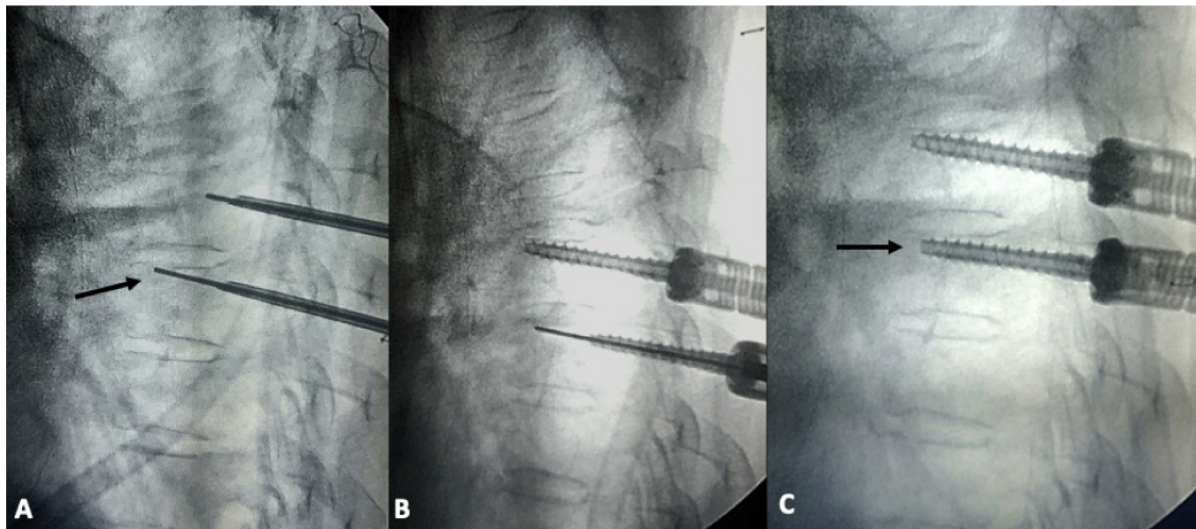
(A) Lateral X-ray showing the K wire abutting the superior endplate (arrow). (B) Lateral X-ray showing screw being passed over K wire with a slight inferior trajectory to avoid violating the superior endplate. (C) Lateral X-ray showing the final screw position (arrow) achieved without violating the superior endplate.
